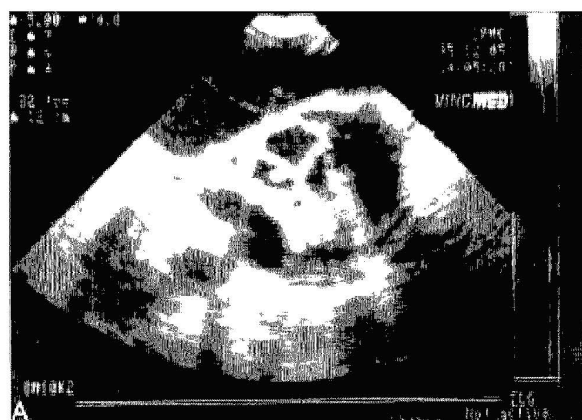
(A) Short axis echocardiogram demonstrates the three leaflets to be fully apposed during diastole. One of the leaflets is slightly redundant. (B) Long axis view demonstrates opening of the leaflets. The lower, redundant leaflet does not open completely.
